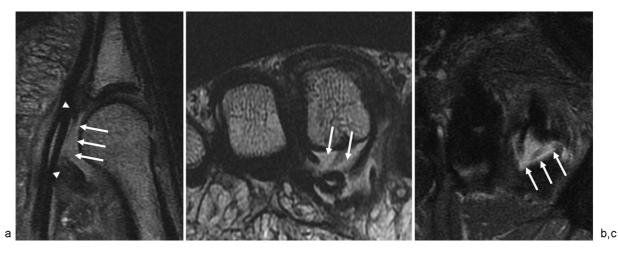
A 30-year-old professional rugby league player presents with chronic second metatarsalgia. (a) Sagittal proton-density (PD) 1.5-T MR image performed in a knee coil demonstrates an extensive longitudinal tear of the plantar plate of the second MTP joint (arrows). Arrowheads indicate the proximal and distal margins of the tear. (b) Short-axis T2 MR image demonstrate the extensive transverse component to the defect (arrows). (c) Long-axis fat-suppressed PD MR image demonstrates the transverse (arrows) and longitudinal components to the buttonhole-type defect.
